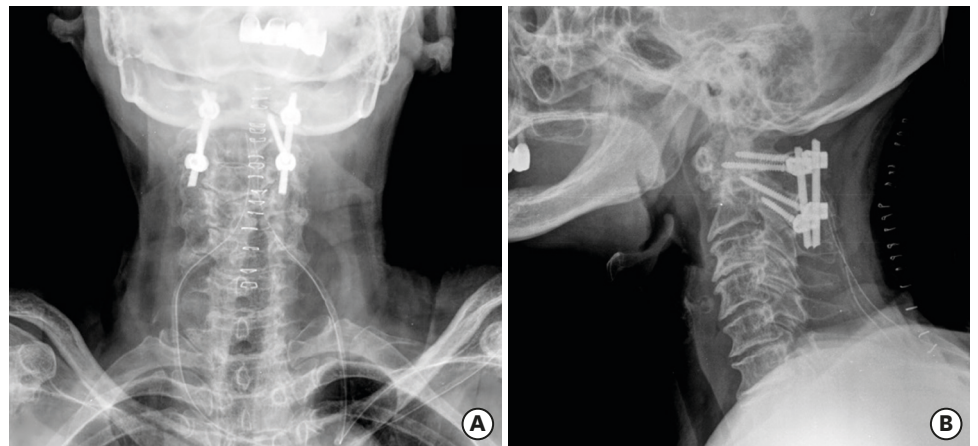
Postoperative plain radiographics. (A) Anteroposterior view and (B) Lateral view.
